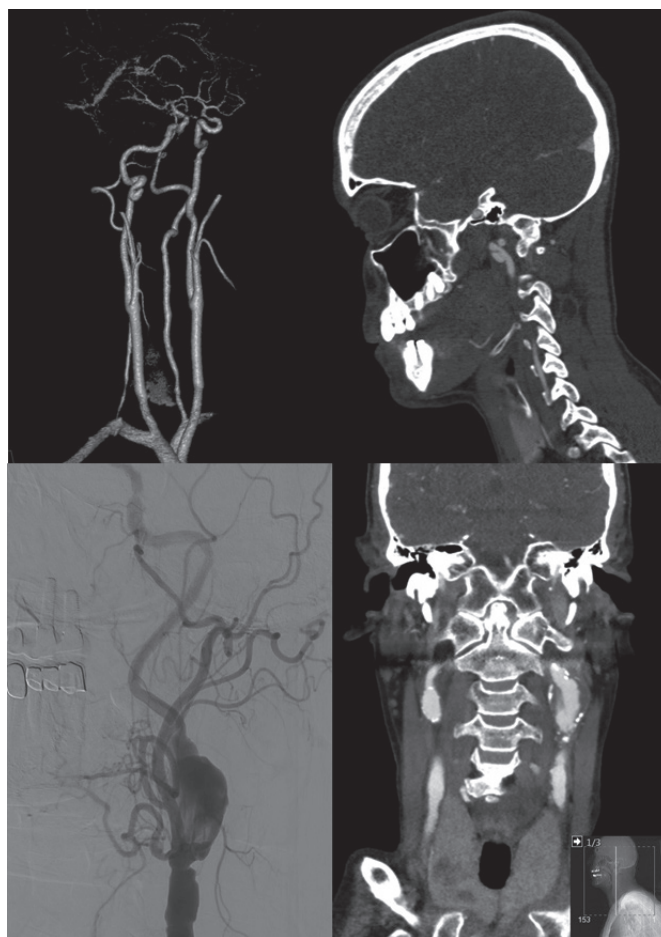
CT angiogram and digital subtraction angiography reconstruction of ECAA patients. (Top) Saccular aneurysm of the right internal carotid artery. (Bottom) fusiform aneurysm of the left internal carotid artery.
